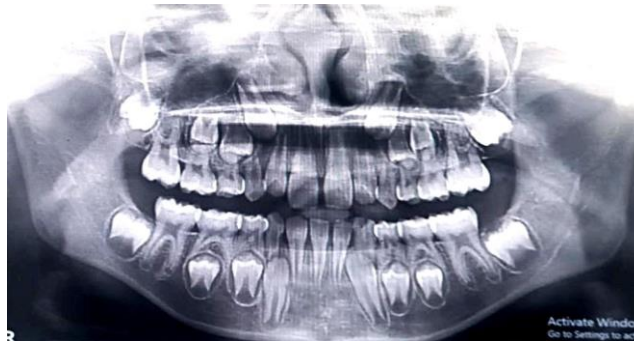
Orthopantomogram showing:
